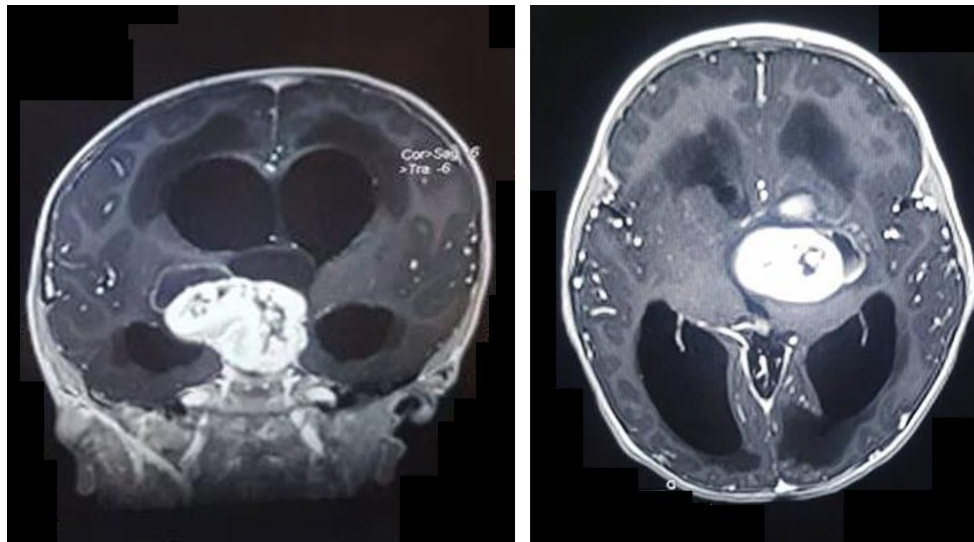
Preoperative coronal and axial postcontrast T1 - Weighted MRI images.
